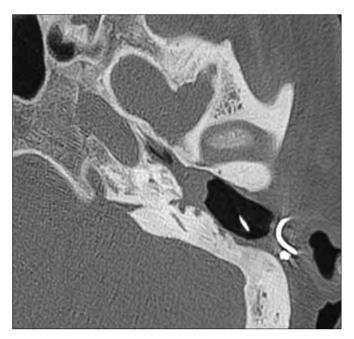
Axial high-resolution CT scan, left ear. Patient 14. The cochlear implant array/connecting cable can be seen in the lateral portion of the cavity. A mass of soft tissue density fills the middle ear cavity and ossification of the cochlear lumen is evident.
